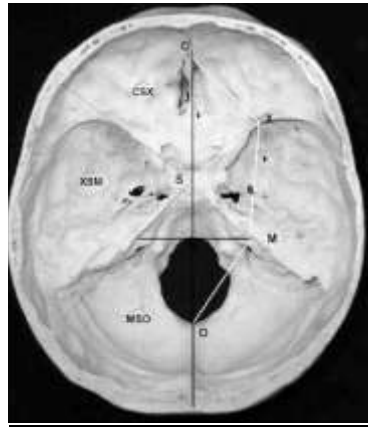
CBCT cranial base measurements
